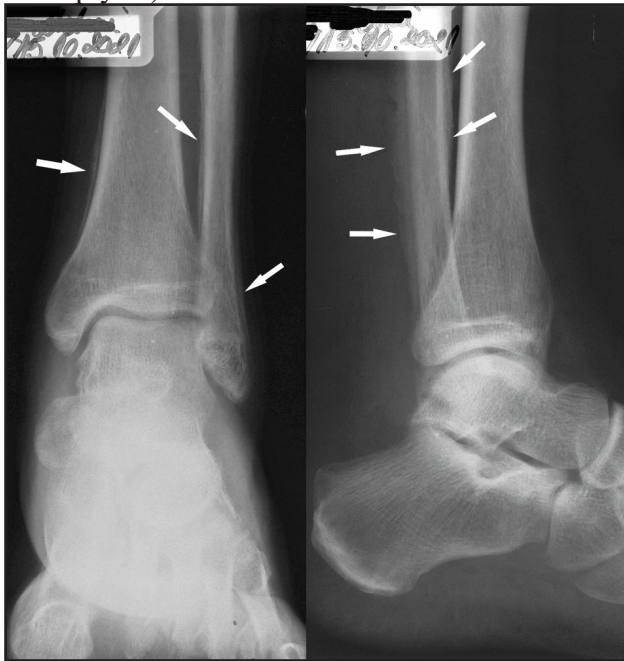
Conventional radiography; The image shows periosteal appositions on the tibia and fibula (arrow)
